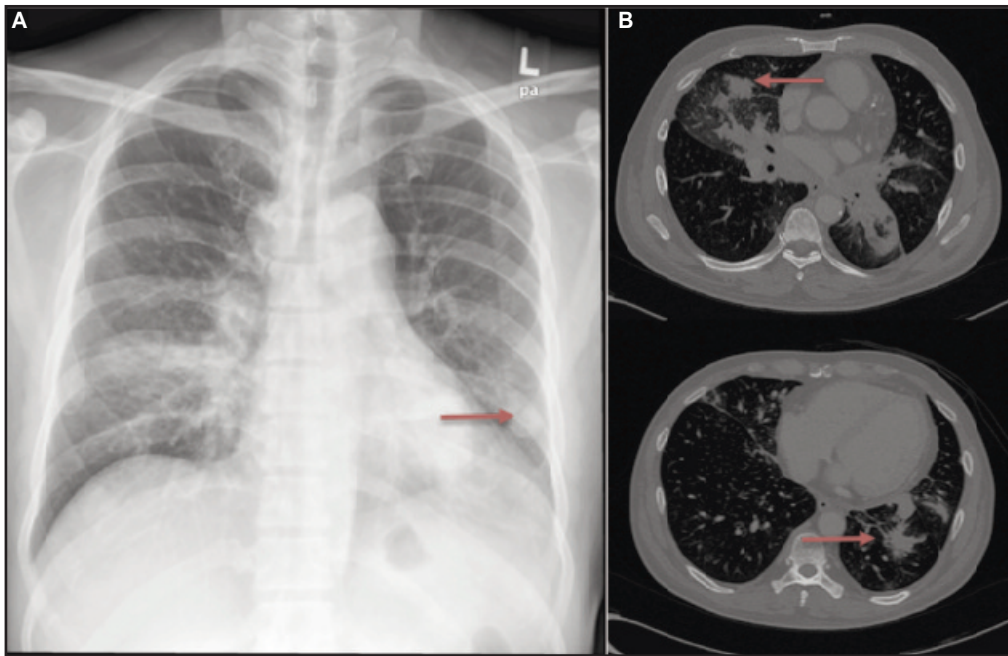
Chest X-ray (1A) showed left lower lobe lung nodule. CT scan (1B) showed multiple lung nodules with no endobronchial involvement.
